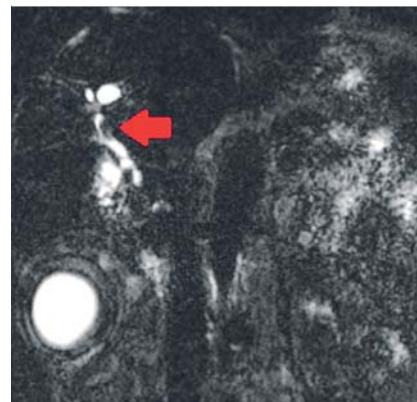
MRI showing polypoid lesion in the common hepatic duct.
